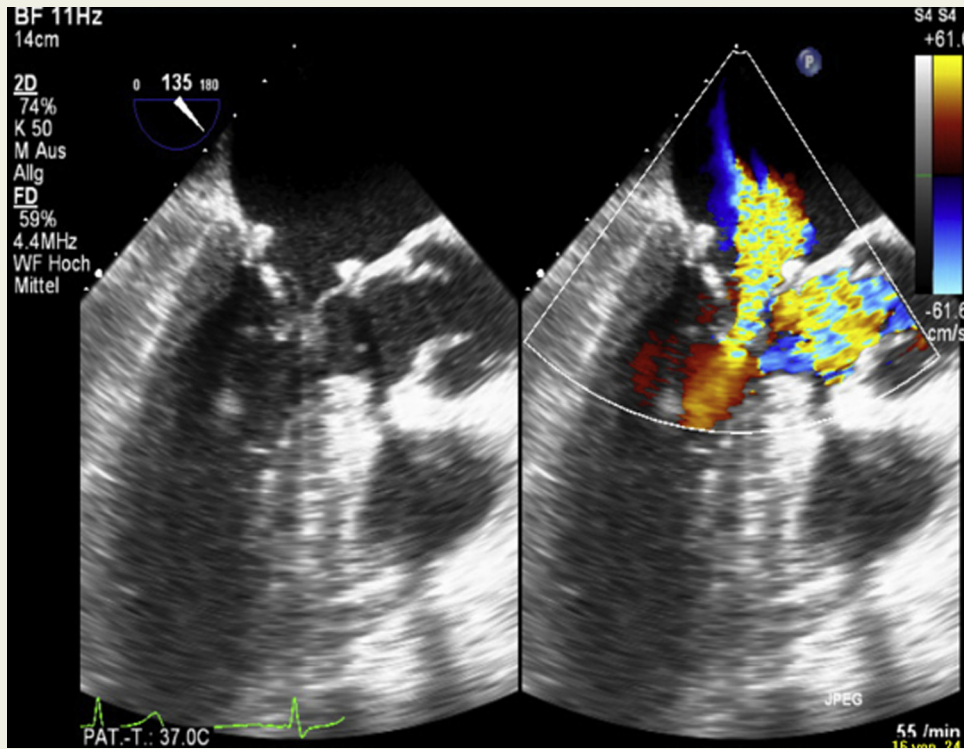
Transoesophageal echocardiography displaying significant mitral regurgitation in conjunction with significant LVOT obstruction due to severe SAM of the anterior mitral leaflet.
